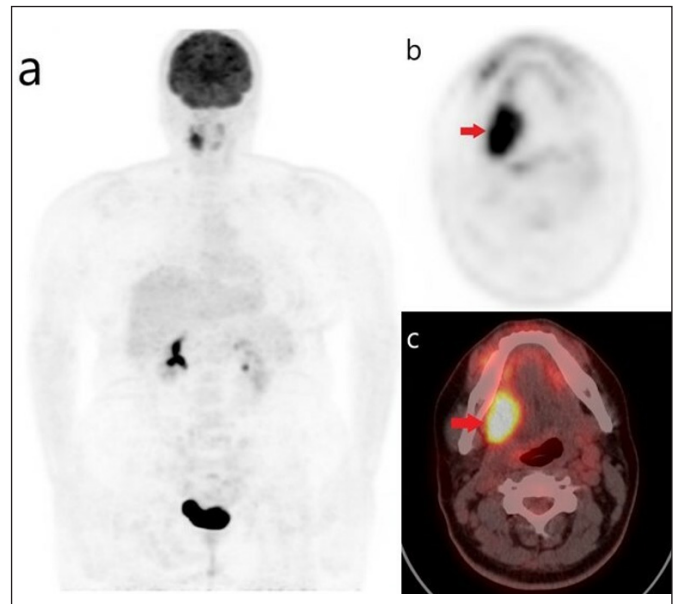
Maximum intensity projection (a), axial ¹⁸F-FDG PET (b) and PET/CT images (c) of a 33-year-old female patient with TSCC. Primary tumor was seen on the right lateral part of the tongue (red arrows). She had pT2-pN0 tumor with PNI but without LVI. The surgical margin was negative, the distance from the closest surgical margin was 2 mm and the depth of invasion was 6 mm. Tumor SUVmax, MTV and TLG were 13.5, 10.37 cm³ and 88.9, respectively. The patient had tumor recurrence at 24 months and had died at 33 months after initial cancer diagnosis.
